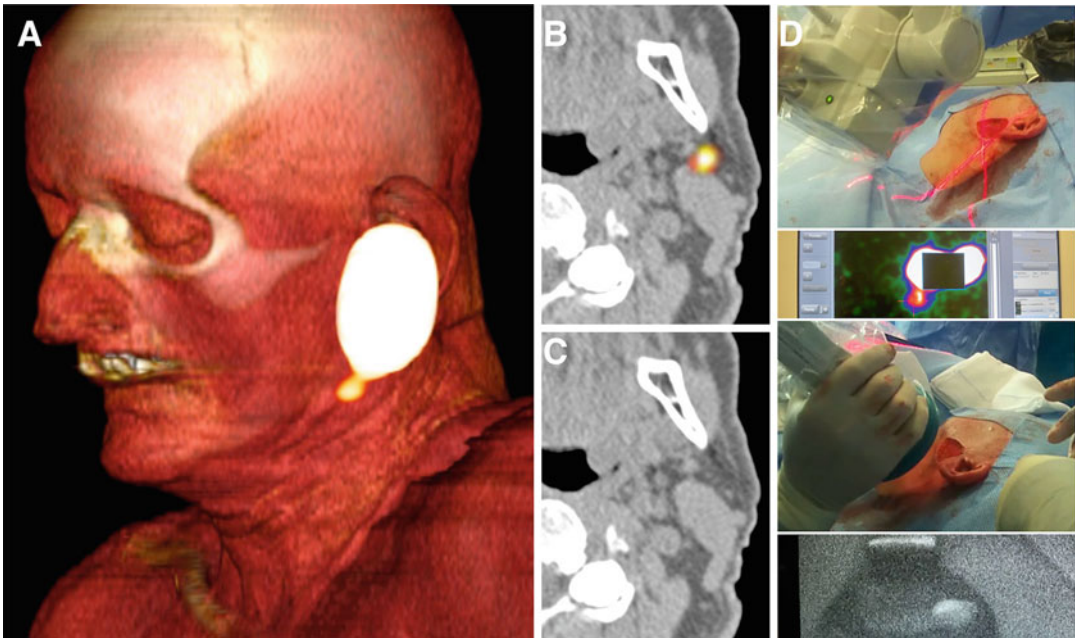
SPECT/CT with volume rendering (a) showing drainage of ^{99m}Tc -nanocolloid to a sentinel lymph node close to the inferior border of the injection site in the left auricular area. This lymph node is further anatomically
